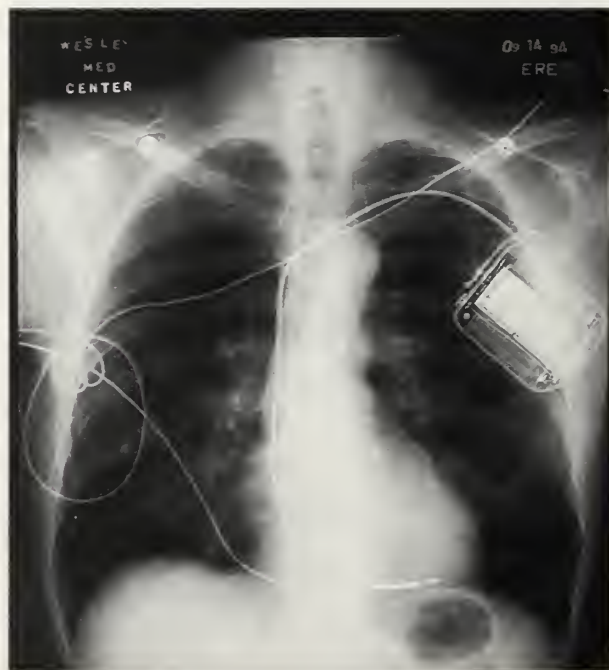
Chest x-ray of a patient with a pectoral implanted Medtronic Jewel 7219C device and a Medtronic Transvene lead at right ventricular apex.
